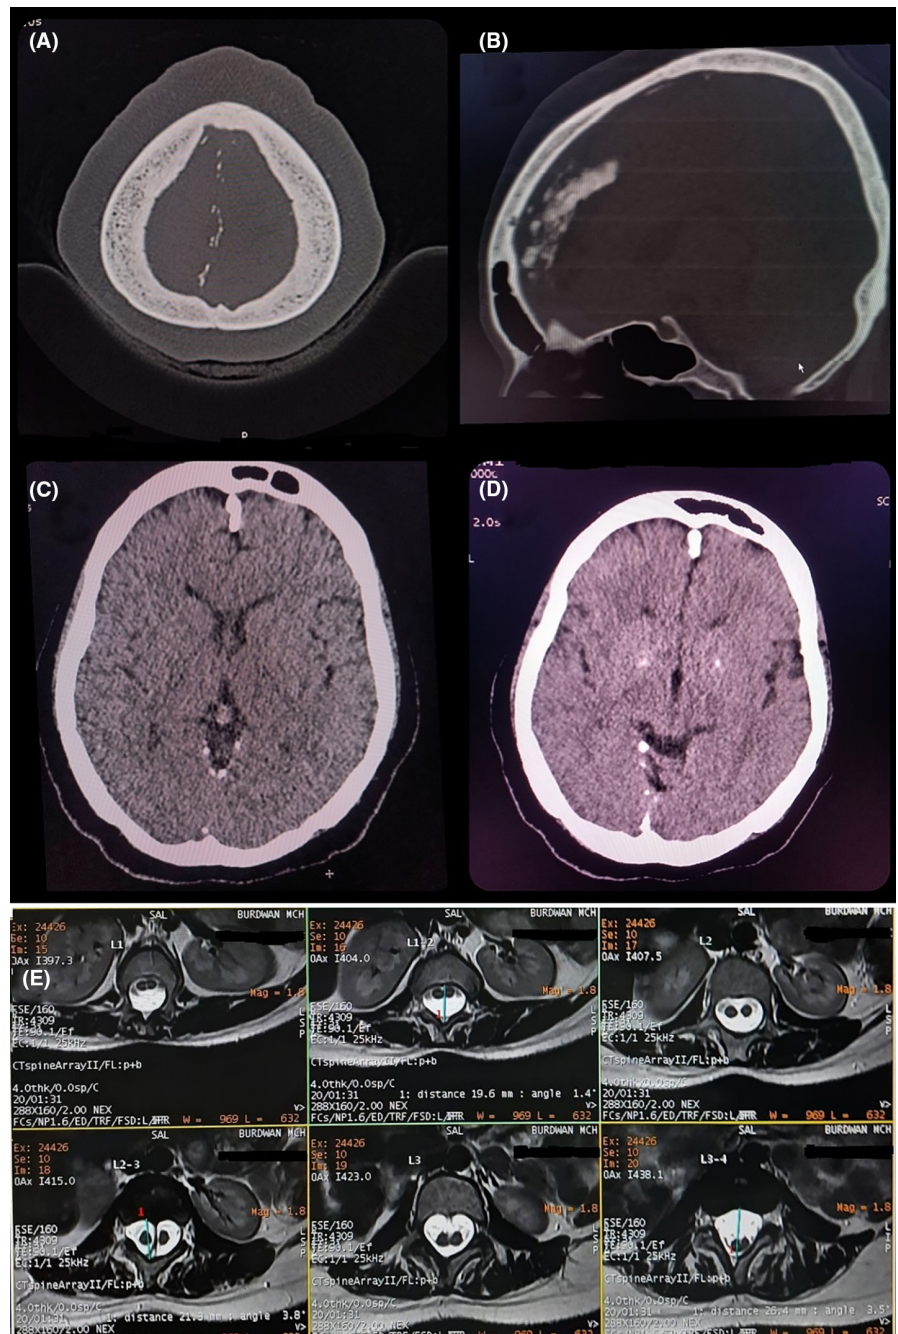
(A–D) Non-contrast CT scan of the brain shows increased calvarial thickening and extensive calcification along falx cerebri, tentorium cerebelli, and mild calcification over bilateral basal ganglia (A and B are axial and sagittal bone windows, respectively; C and D are axial parenchymal windows). Alongside, there is partially bridged sella turcica, as shown in image B. (E) MRI of the lumbosacral spine (axial T2-weighted image) showing diastematomyelia at L1 to L3–L4 level.
